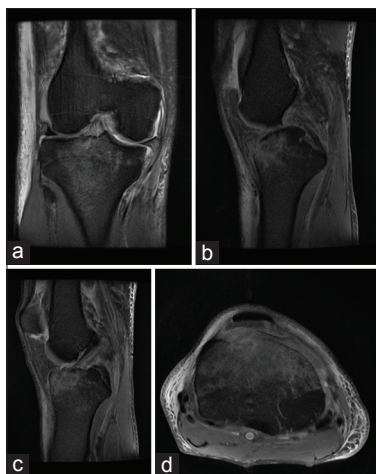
Axial, coronal, and sagittal PDFS MRI knee images showing (a,b,d) classical pattern of bone marrow edema in dashboard injury involving anterior tibia. (b,c) PCL tear is seen, with relatively intact ACL
